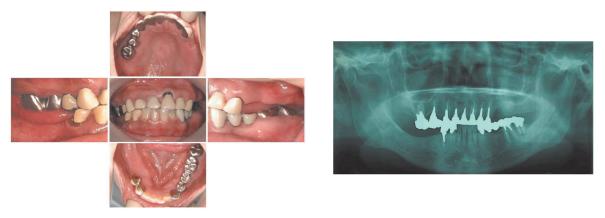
Oral Photo and Panoramic X-ray Photo (First examination)
